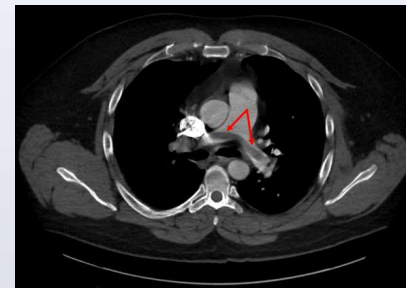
Axial CT demonstrating saddle pulmonary embolus extending into bilateral pulmonary arteries
